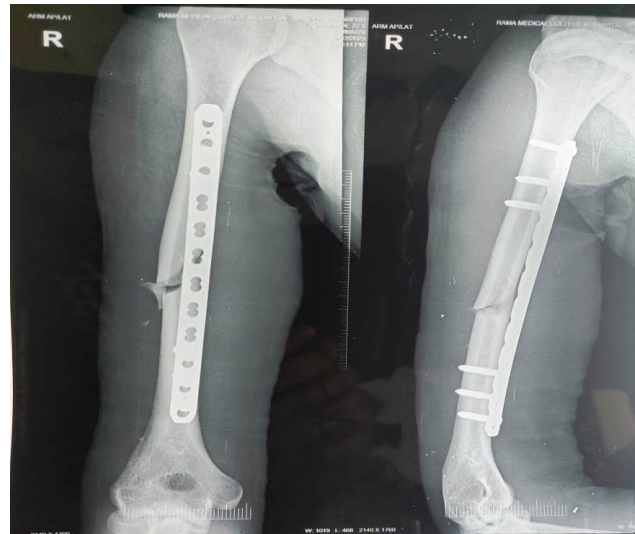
Immediate Post-Operative X-Ray showing LCP with MIPO technique.
